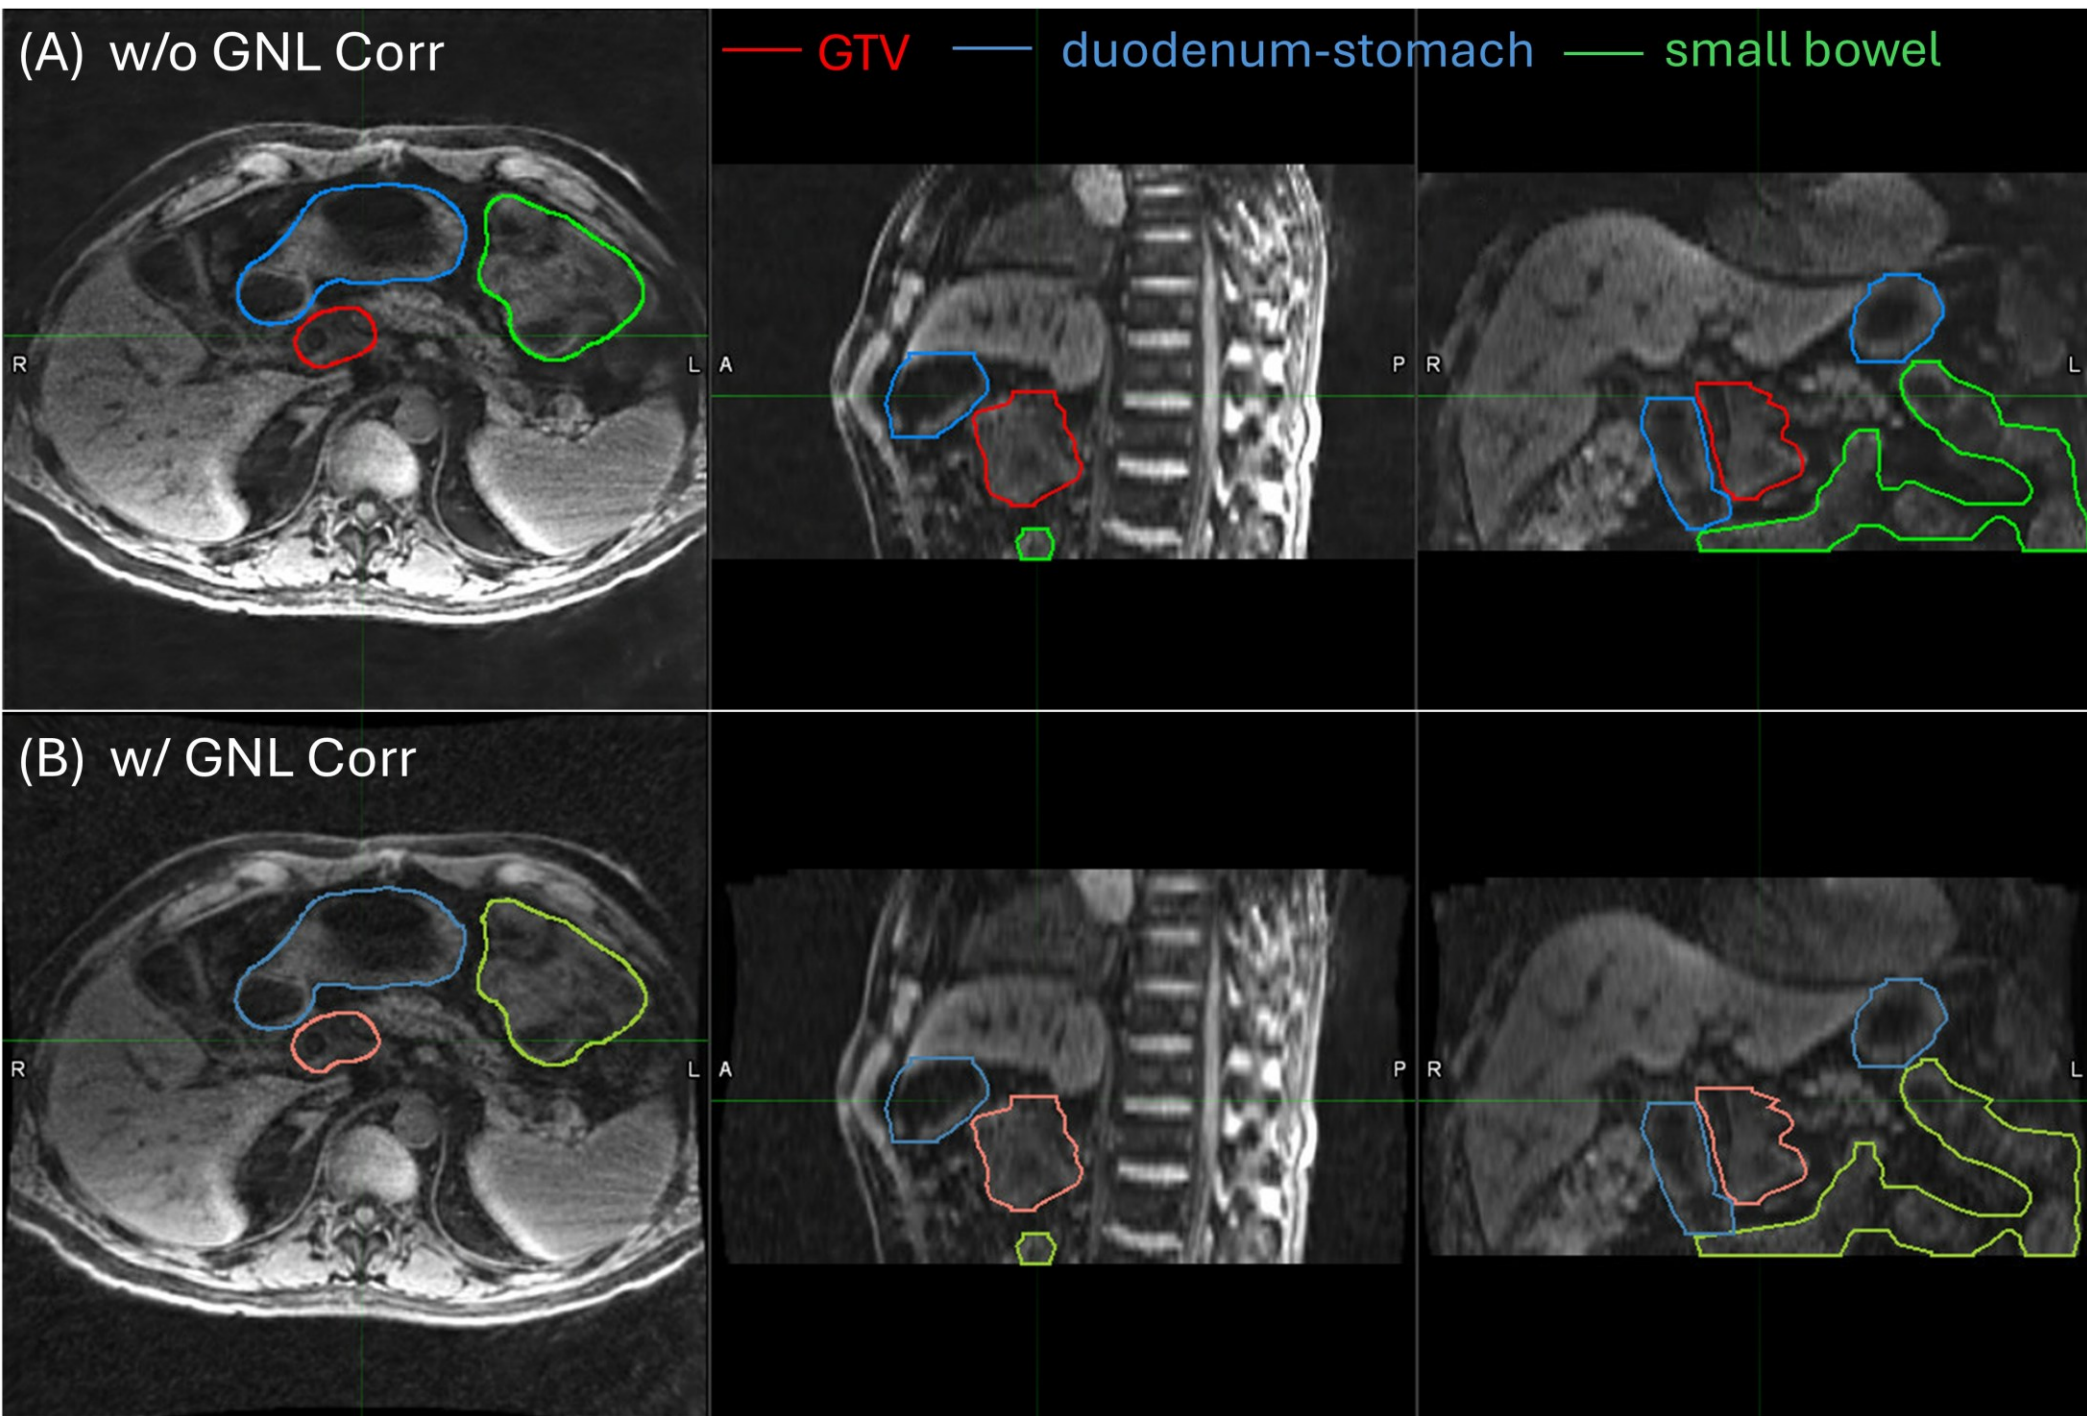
End-exhale phase of 4D MRI from a pancreatic cancer patient showing the gross tumor volume (GTV), duodenum-stomach, and small bowel contours before (A) and after (B) gradient nonlinearity (GNL) correction.
